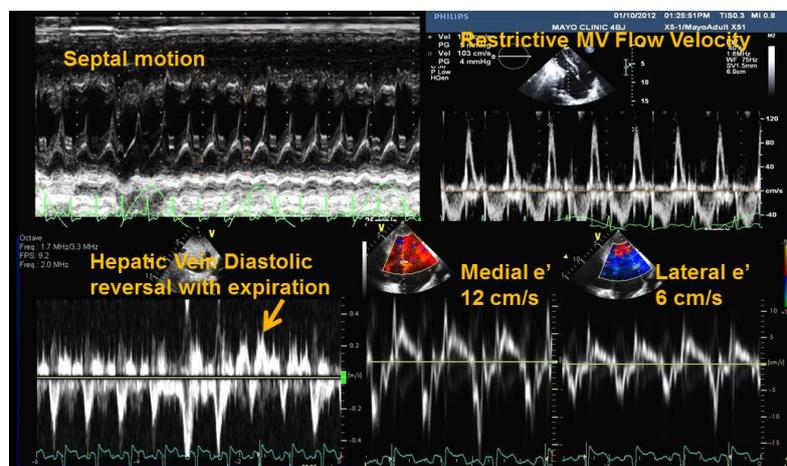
Echocardiography Diagnostic Criteria for Constriction [25]
